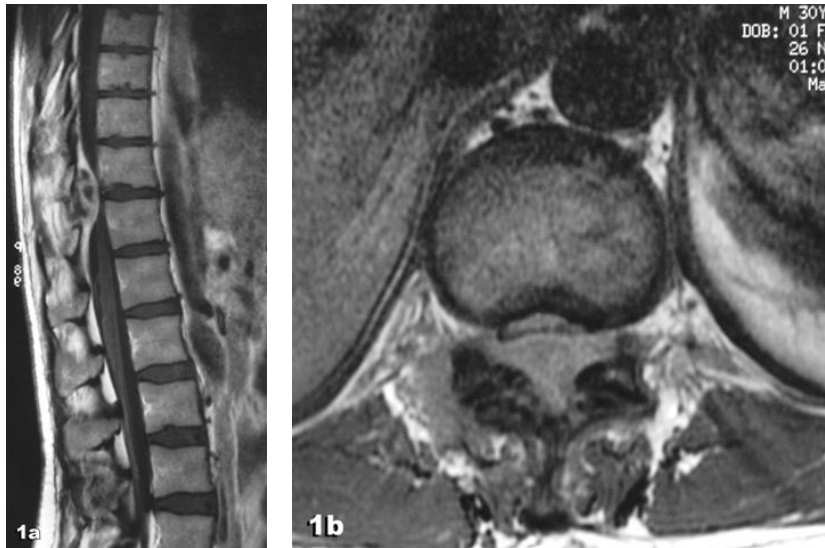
A, B, T2-weighted MRI showing cord compression.
